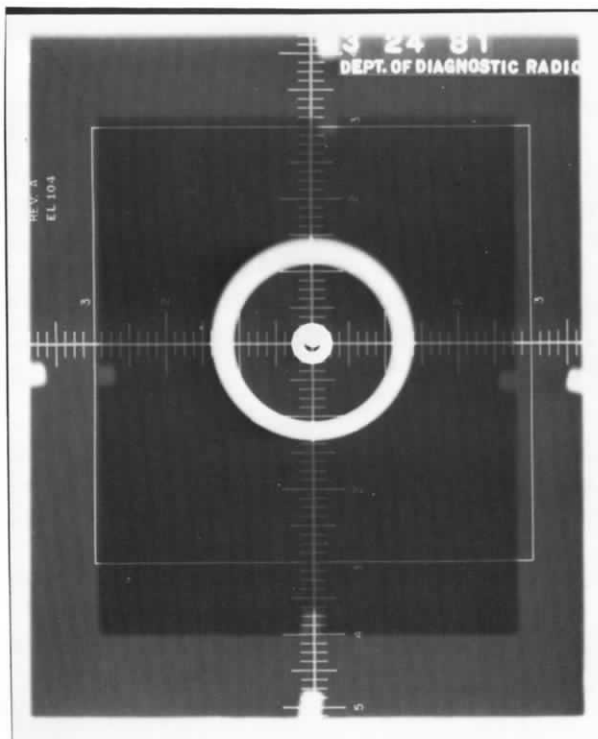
X-ray beam perpendicularity is acceptable but the lower collimator leaf extends out too far (left film) and the film from the Bucky tray (right) indicates that the cassette was not centered properly.
